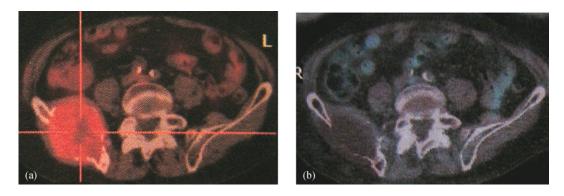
PET-CT from a patient with iliac metastasis from multiple myeloma. (a) Pretreatment PET-CT image showing positive of the tumor; (b) one month posttreatment, PET-CT image showing negative of the tumor. Courtesy of Dr. Franco Orsi from the European Institute of Oncology, Milan, Italy. PET: positron emission tomography; CT: computed tomography.
